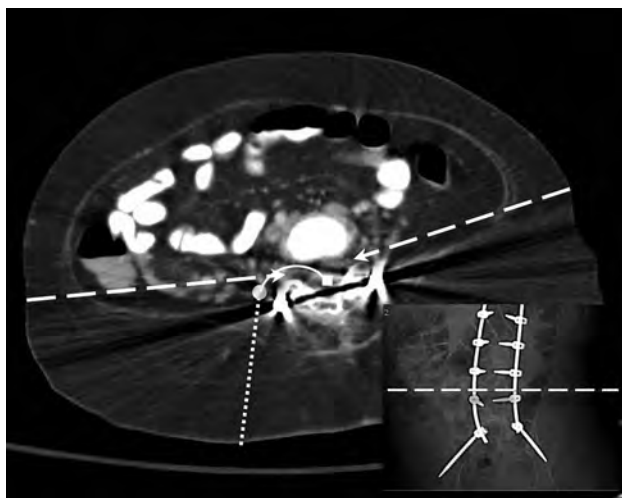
Axial CT obtained in the same patient depicted in Figure 2 near the time of procedure but for an unrelated indication annotated to depict approximate trajectory and ending points of the outer guiding needle and curved inner needle using curved needle technique. *Dotted line* indicates guiding needle trajectory. *Circle* indicates guiding needle termination. *Solid line* indicates curved needle trajectory. *Square* indicates curved needle termination. *Dashed arrows* indicate hypothetical right and left straight needle trajectories at this level in this patient. *Insert*: corresponding AP scout image *dashed line* indicates plane of imaging.
